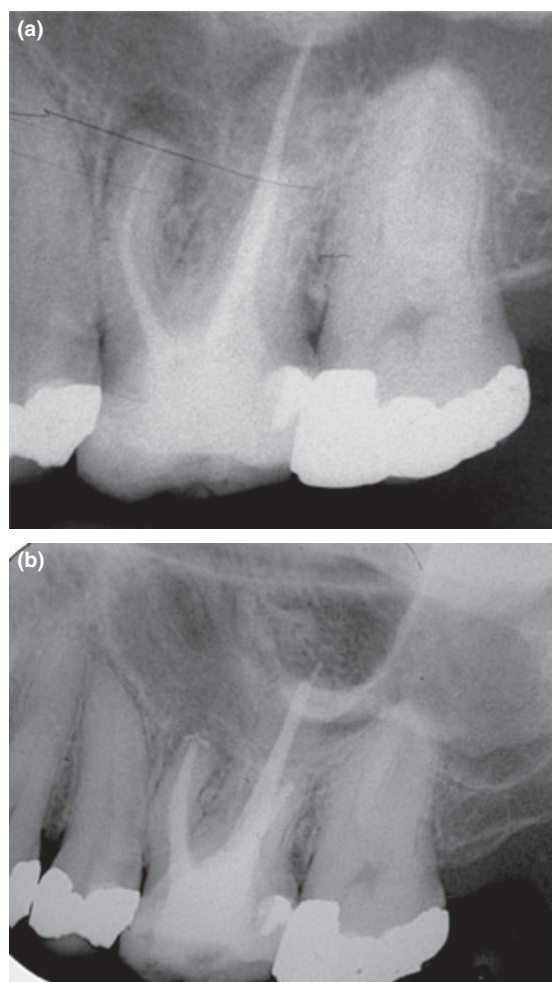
(a) Preoperative periapical radiograph showing tooth 26 with previous root canal treatment and core build-up. (b) Postoperative radiograph taken after root canal retreatment.
